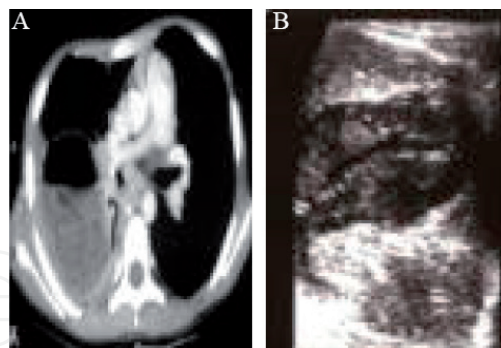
Type 4 hydatid cyst: (A) sagittal contrast enhanced CT images of thorax show ruptured type 4 hydatid cyst in the lower lobe of the right lung with wrinkled floating endocyst-so called “lily sign” and (B) oblique ultrasonogram shows type 4 hydatid cyst.
